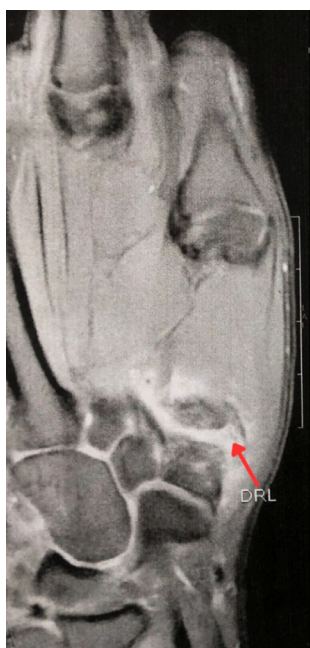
Focused right-hand MRI revealed a total tear of the dorsoradial ligament (DRL) (red arrow). This ligament normally extend from trapezium to the first metacarpal base.
